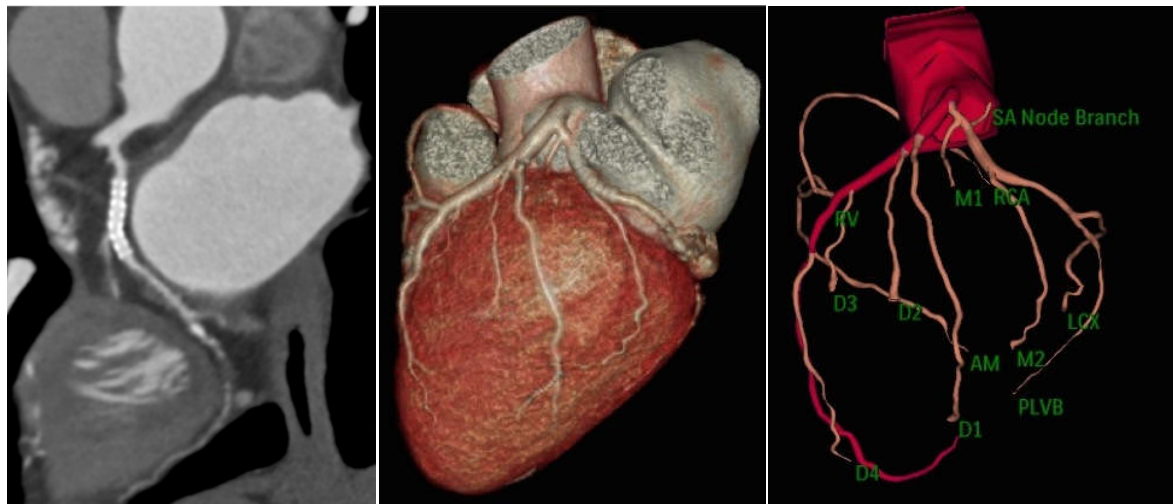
55 years old male with PCI to LCX presenting with chest pain. TRO CT, MPR curved (a), 3D (b) & coronary tree (c) views shows patent LCX stent
